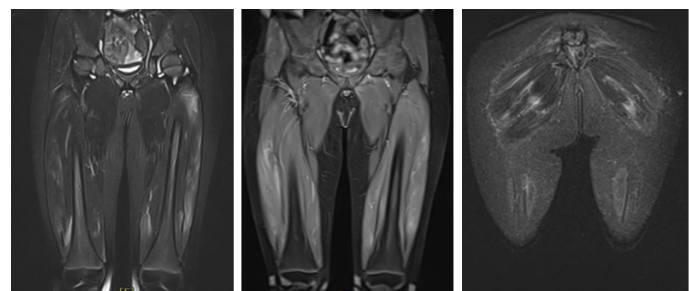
MRI with the contrast agent showed multiple foci myositis of bilateral gluteal and femur regions.
